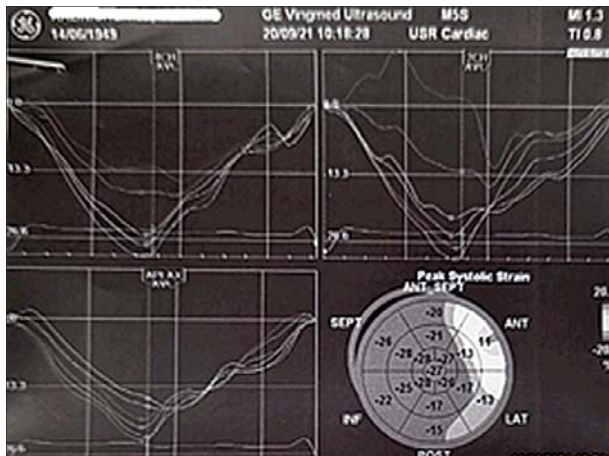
Stress echocardiography during restitution period
